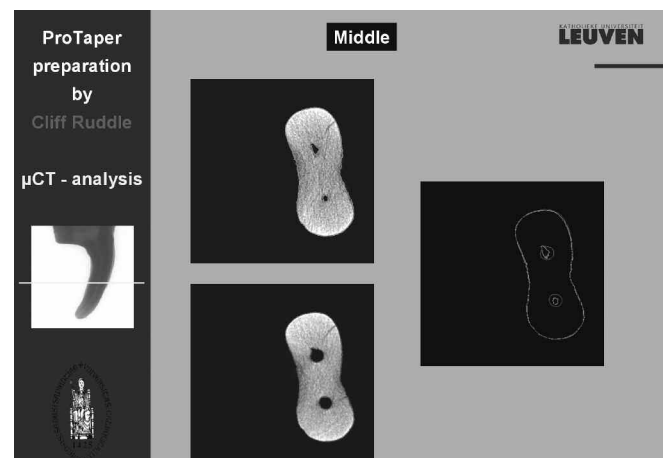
This figure reveals horizontal μ CT sections through the “middle” one-third of the root. Note the ProTaper shapes are round and centered within the root.
